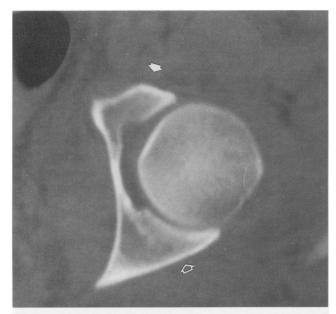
Further caudally, note the anterior (solid white arrow) and posterior (hollow white arrow) walls. This CT cut is at the mid-level of the joint.
